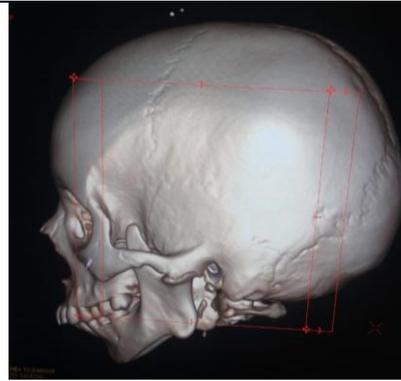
CT scan showing ankylotic mass with high coronoid growth (left)
